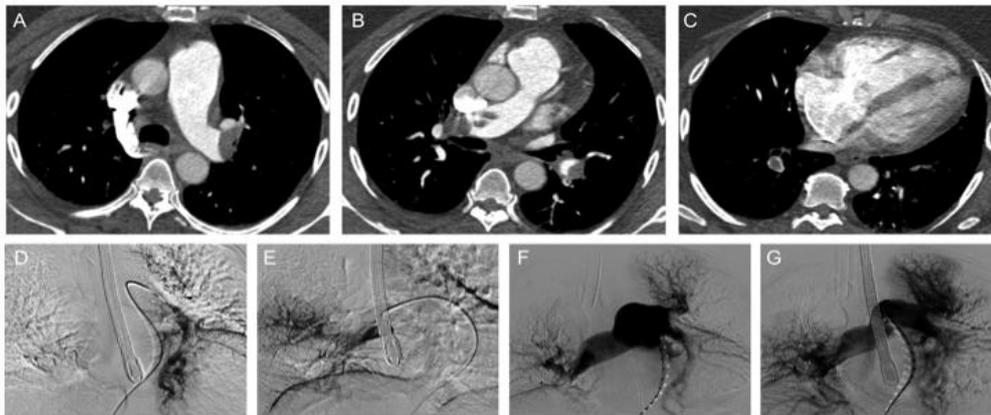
A, B) Pre-intervention CTA demonstrating saddle PE and extensive embolic burden extending into the lobar, segmental and subsegmental branches. C) Right heart strain demonstrated on CTA by visualization of right ventricular dilatation and flattening of the interventricular septum. Note the segmental embolus adjacent to the arrow. D, E) Bilateral selective lobar pulmonary artery catheterization with infusion of alteplase. F, G) Pulmonary angiogram immediately following treatment showing considerable improvement in pulmonary perfusion.
